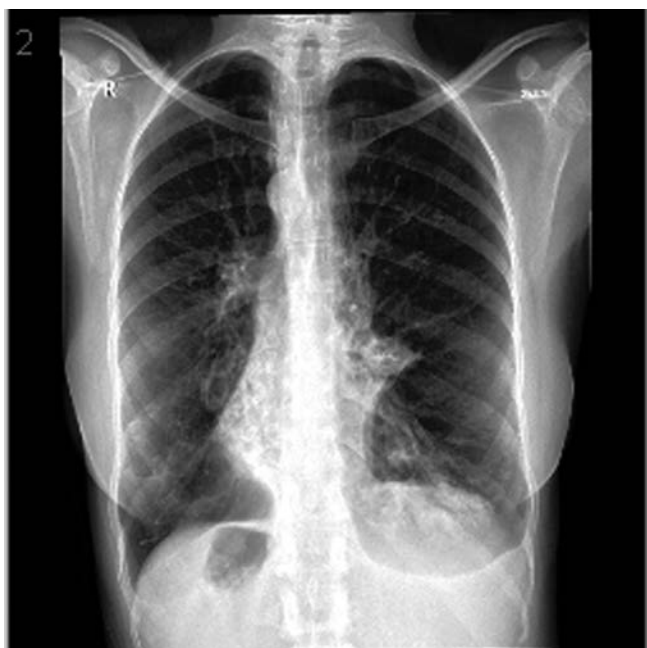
Case 2: Chest radiograph showing dextrocardia with bronchiectasis.
